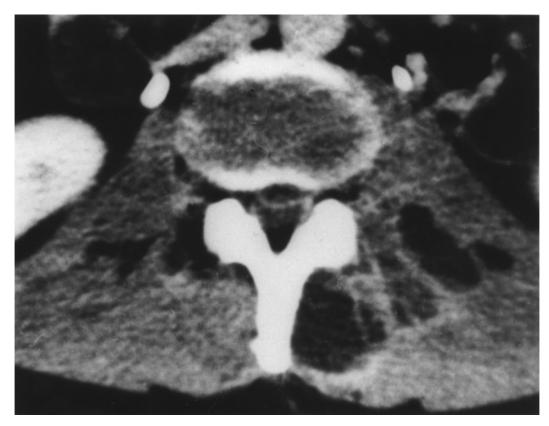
Spinal cord epidural abscess: CT with contrast of 28 year old man with urinary hesitancy, marked back pain and mild proximal leg weakness with increased tone. Blood cultures grew *S. aureus*. Scan shows enhancing rim of dura projecting from disc space into spinal canal, and hypodense lesion with enhancing membranes in the right psoas muscle which is where abscess began.
